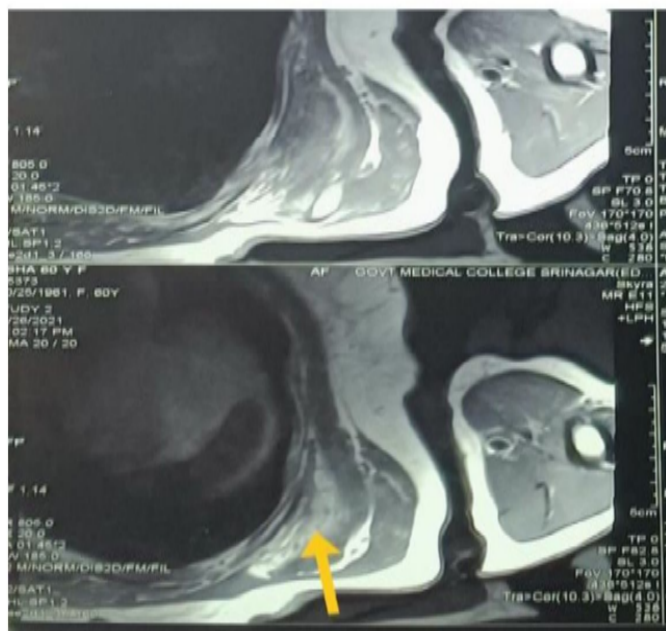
MRI scan demonstrating elastofibroma dorsi
